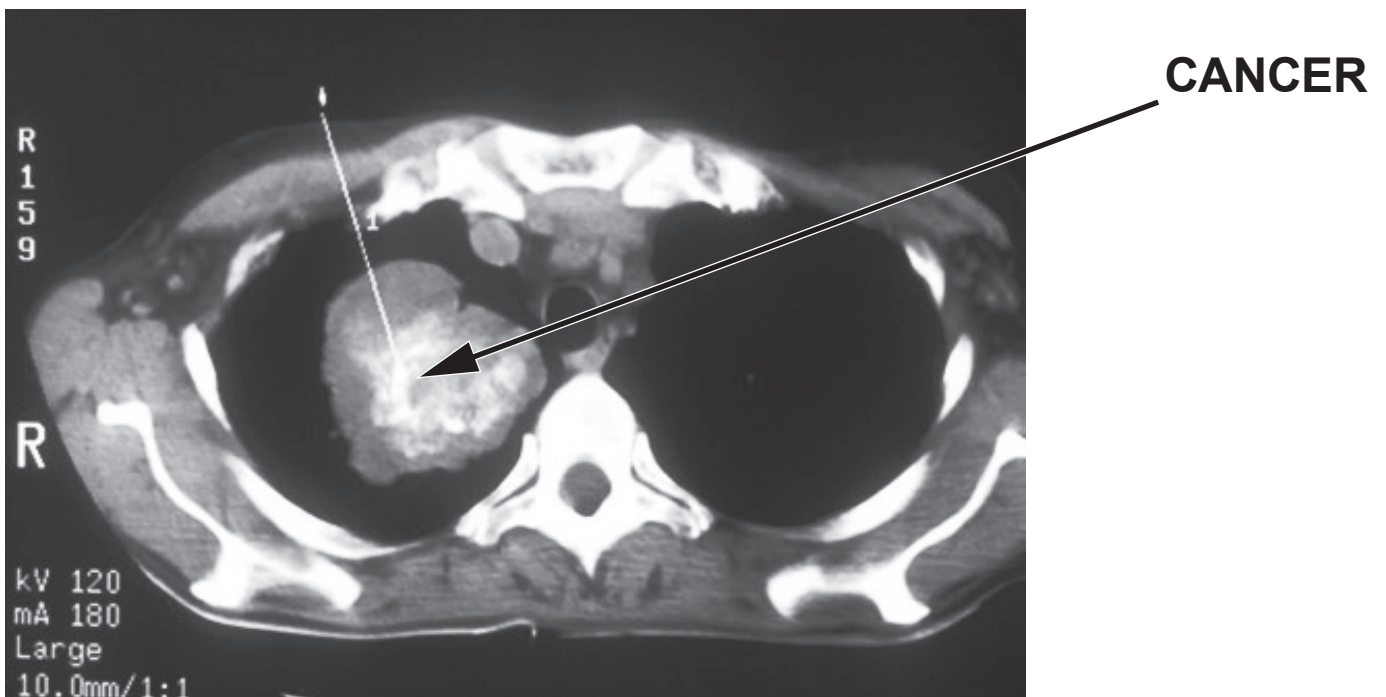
CHEST X-RAY OF PERSON WITH LUNG
